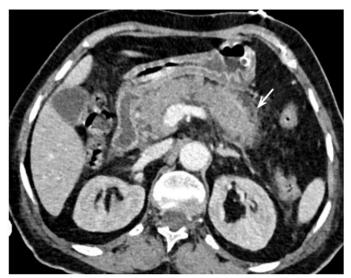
CT images of stage E pancreatitis.
